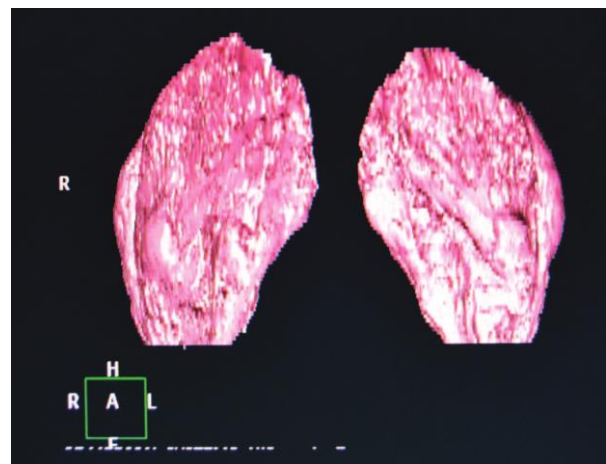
Preoperative volumetric evaluation by computed tomographic scan.
